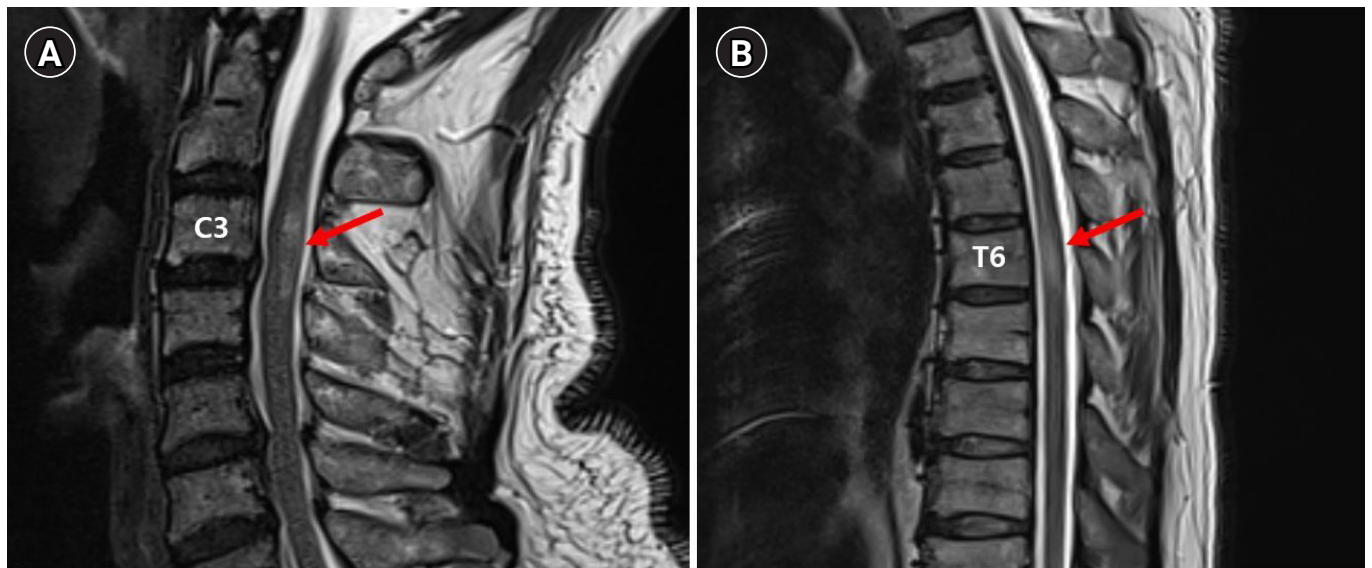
(A) Image showing high signal intensity between C3 and C4 level (arrows) at day 2 on T2 weight magnetic resonance imaging (MRI). (B) Image showing high signal intensity on T6 level at day 2 on T2 weight MRI.
